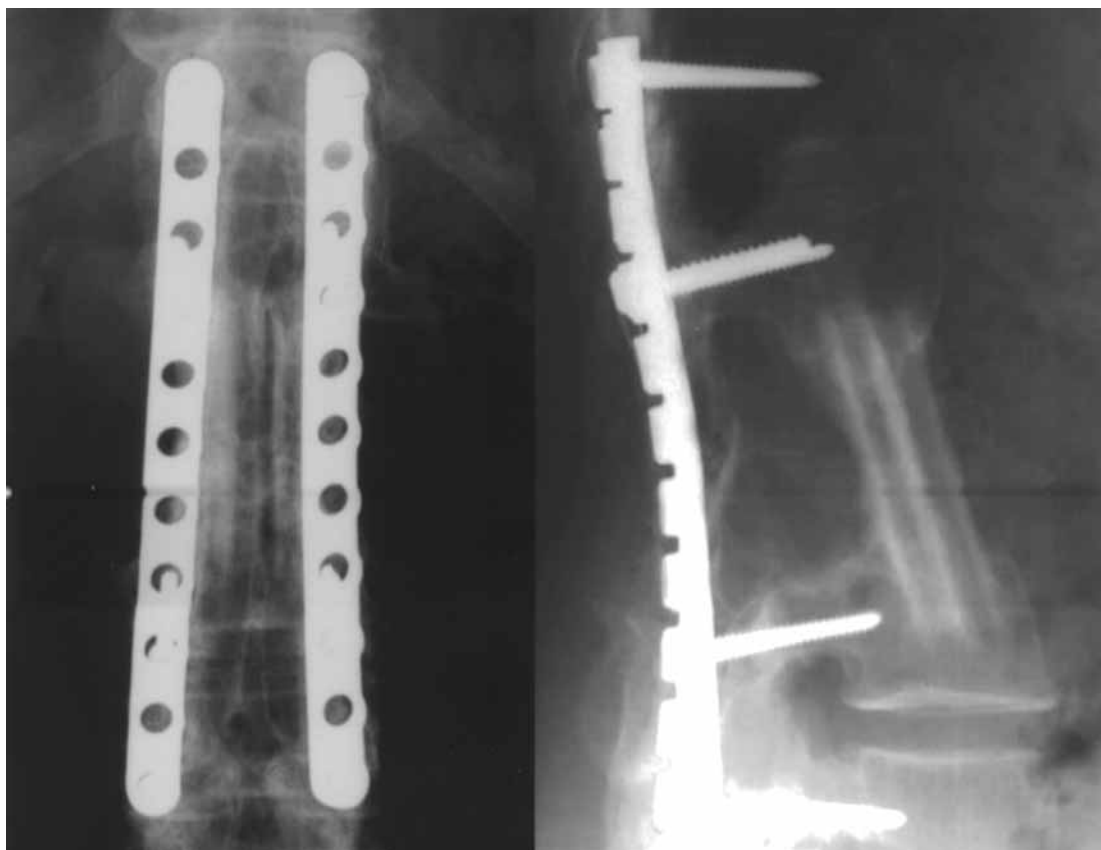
Radiographs taken seven years after surgery showing instrumentation and union of bone grafts without signs of recurrence.
